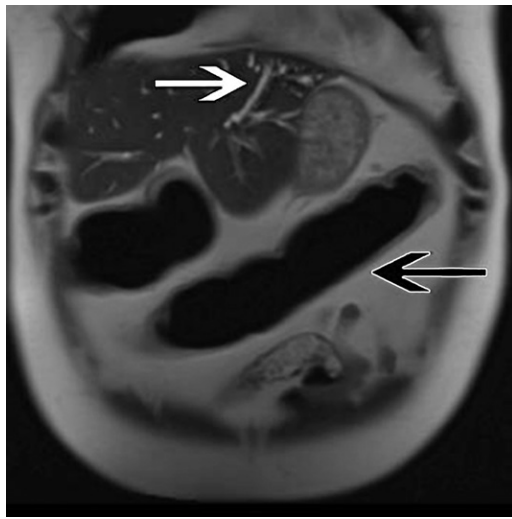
Ulcerative colitis in a 31-year-old man with clinically unsuspected PSC. Coronal T2-weighted MR enterographic image shows a segment of featureless transverse colon with loss of haustral markings consistent with ulcerative colitis (black arrow). Abnormally dilated bile ducts (white arrow) are depicted within the left hepatic lobe, findings consistent with concomitant PSC.
